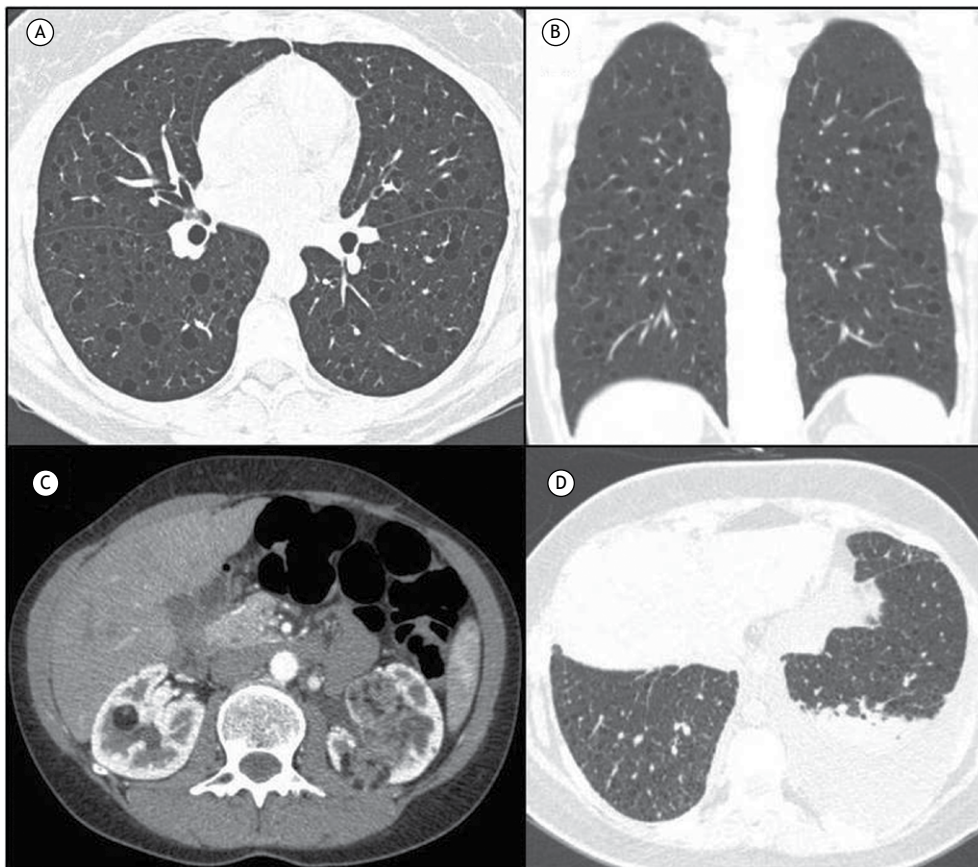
In A, axial reconstruction and, in B, coronal reconstruction of chest CT scans of a female patient with lymphangioliomyomatosis, showing diffuse lung cysts with regular walls. In C, axial reconstruction of an abdominal CT scan of a female patient with lymphangioliomyomatosis, showing bilateral, heterogeneous renal masses, consistent with angiomyolipoma. In D, axial reconstruction of a CT scan of a female patient with lymphangioliomyomatosis, showing diffuse lung cysts and a left chylothorax.
